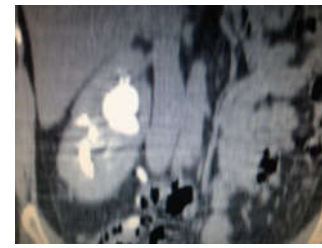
CT KUB showing Upper calyceal diverticulum.
